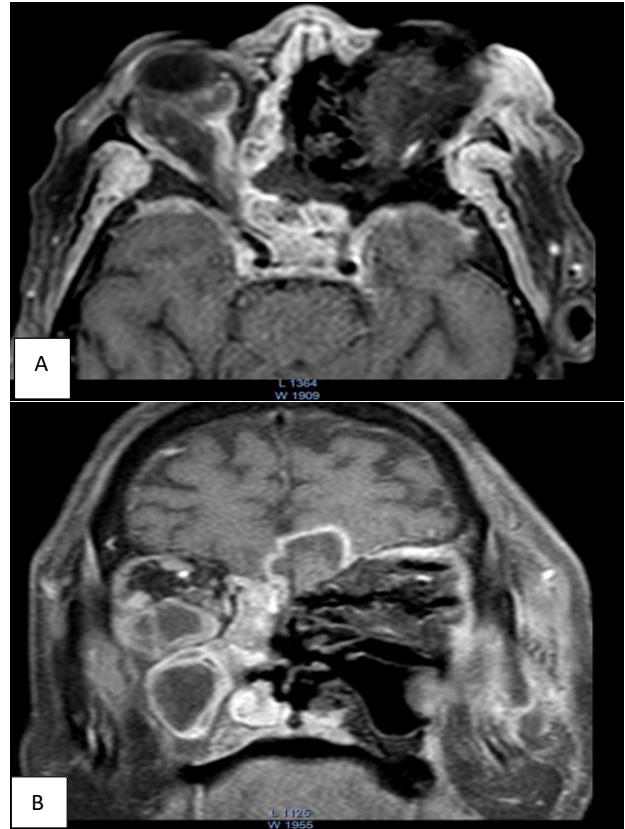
(A and B): Post contrast T1W FS MRI orbit and PNS axial and coronal sections revealing heterogeneously enhancing lesion with non-enhancing hypo intense areas involving B/L maxillary, ethmoid and sphenoid sinuses with invasion of intra and extra-conal compartment of V/L orbit, involvement of bilateral optic nerves, extra ocular muscles, orbit apex, left cavernous sinus with involvement of left ocular globe and intracranial extension. Attenuated caliber and luminal irregularity of B/L ICA and left cavernous sinus thrombosis noted. Non enhancing left inferior nasal turbinate (black turbinate sign) also present.
